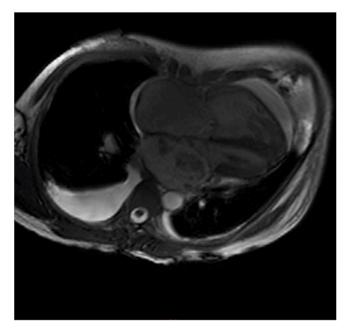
4 chamber view MRI.
